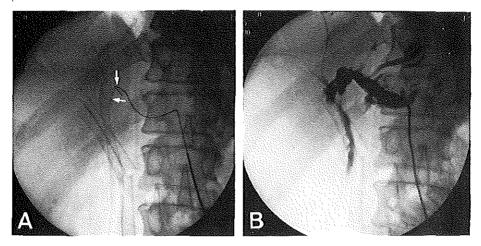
Type III hilar stricture in a patient with cholangiocarcinoma, which was treated with complete drainage by using a right-sided Wallstent Y configuration and a long Wallstent on the left. After eight months symptoms recurred. (a) Radiograph demonstrates angling of the left-sided Wallstent (arrows indicating angulation). The guide wire indicates the more distal part of the left hepatic duct. The relationship between the right segmental stents and the distal stent has changed; one has lost contact with the distal stent. (b) Cholangiogram by the left-sided catheter reveals contrast material in right lobe ducts indicating communication between the parallel stents.
